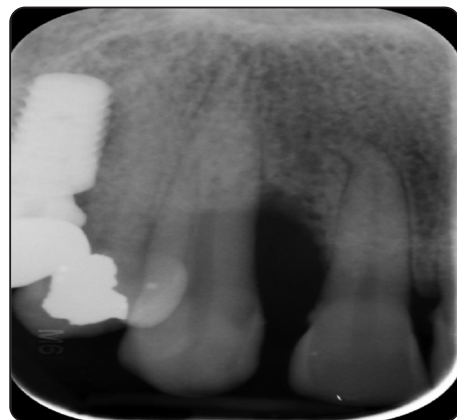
Intraoral periapical x-ray showing vertical bone loss.
